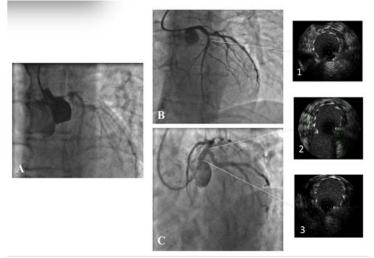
Left main PCI example (continued). The diffusely diseased LM with a critical ostial stenosis (A) has been treated with PCI to obtain a good angiographic result (B, C). Intravascular ultrasound control verified good stent expansion and apposition in the proximal LAD (1), with good opening of the stent cells at the LCX ostium (2) and also good stent expansion and apposition in the LM body (3).
